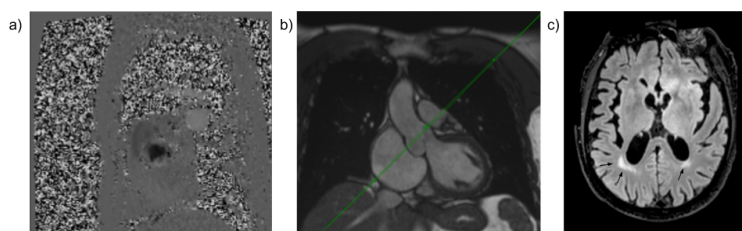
a) Aortic valve flow imaging, view obtained from the plane represented in the left ventricular outflow tract (LVOT) cine b); c) T2 FLAIR image in which white matter hyperintensities (WMHs) are visible.
